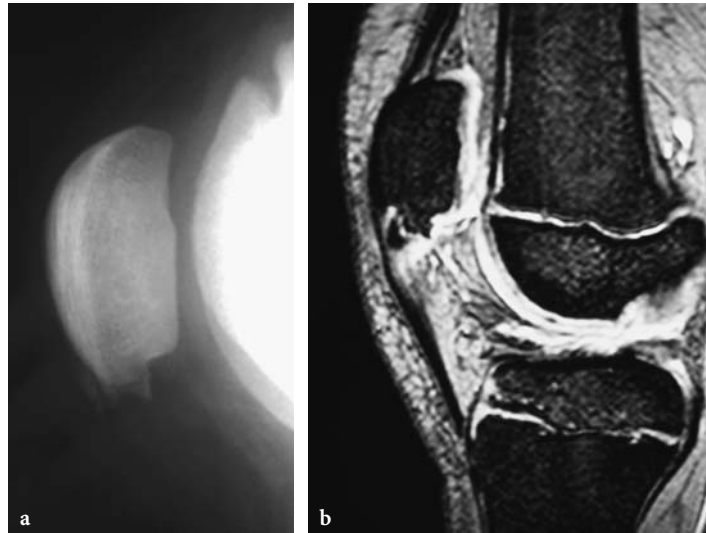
Sinding-Larsen Johansson syndrome a plain film; b T2 gradient echo sagittal image showing fragmentation of the inferior pole of the patella. On MRI there is bony fragmentation and high signal in the adjacent tendon
